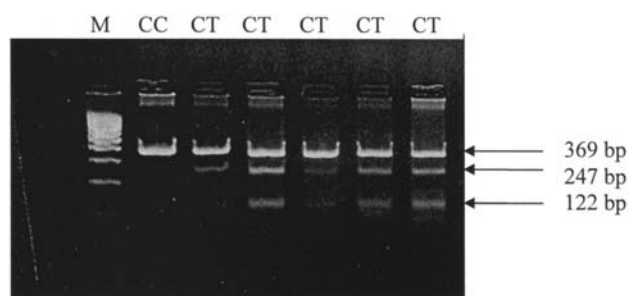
HgaI* restriction pattern of the FXII C46T polymorphism, observed in six patients. CC, homozygote; CT, heterozygotes; M, molecular weight marker.
